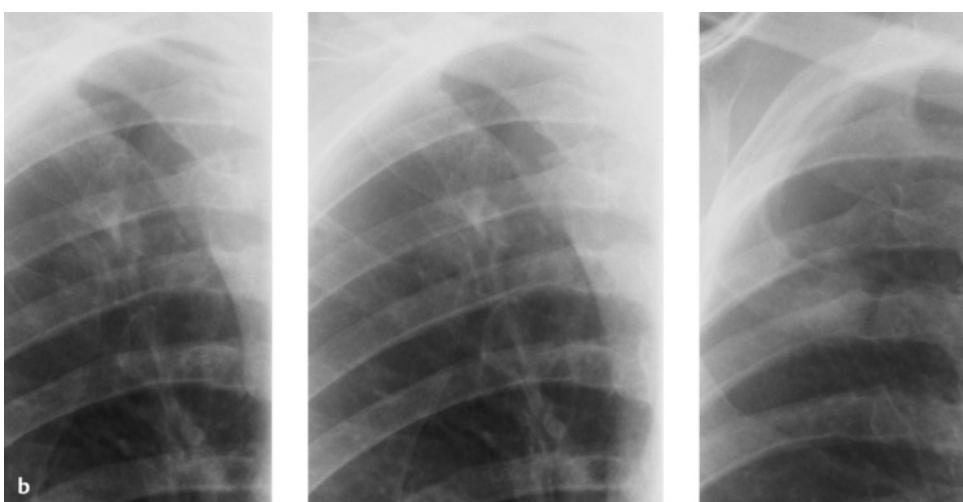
a,b Plain chest radiograph of a male smoker prior to cardiac catheterization (a); fluoroscopy examination of the same patient (b).
